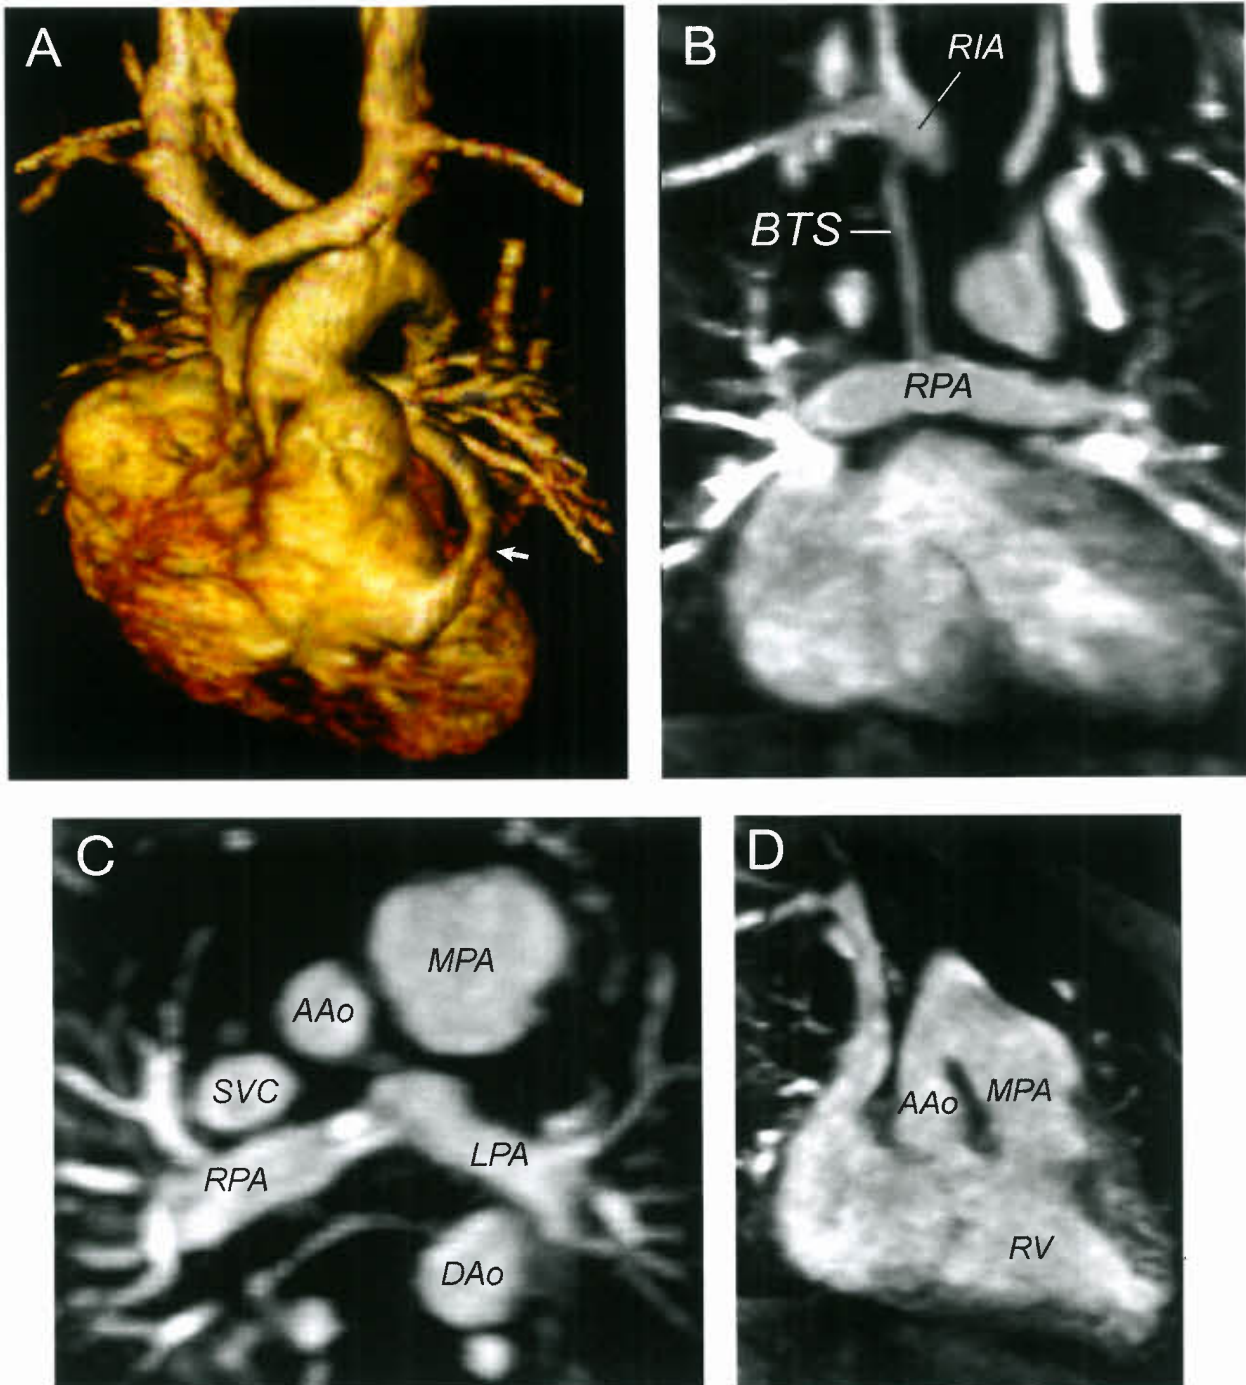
MRI evaluation of hypoplastic left heart syndrome after stage I palliation. A: Volume rendered reconstruction of Gd-enhanced 3-D MRA showing the RV-to-pulmonary artery conduit (*arrow*) and the arterial anastomoses; B: maximal intensity projection of a modified right Blalock-Taussig shunt (BTS); C: maximal intensity projection image in the axial (transverse) plane showing the branch pulmonary arteries; D: maximal intensity projection image showing the anastomosis between the main pulmonary artery and the native ascending aorta; (*Continued*)
